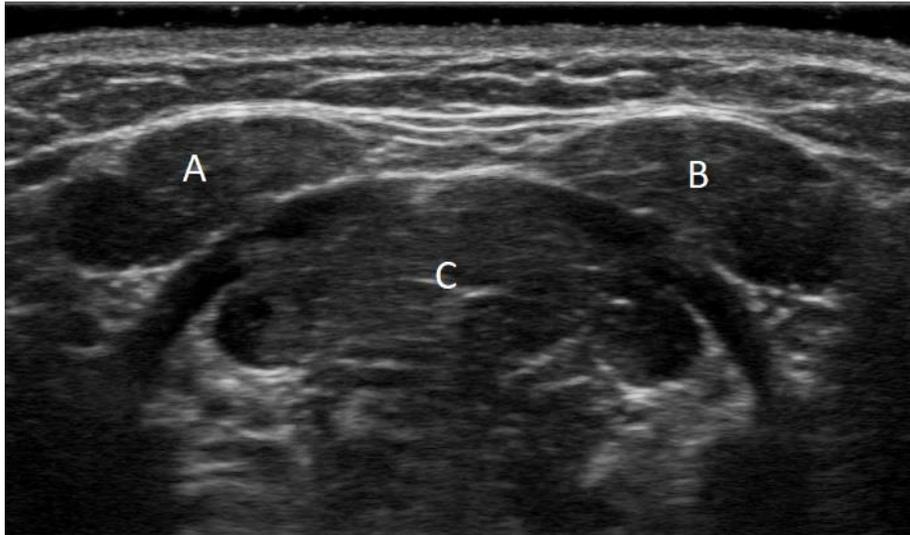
Ultrasound image of CSA of submental muscles, A- left anterior belly of the digastric muscles, B-right anterior belly of the digastric muscles, C- GH+ muscles.
